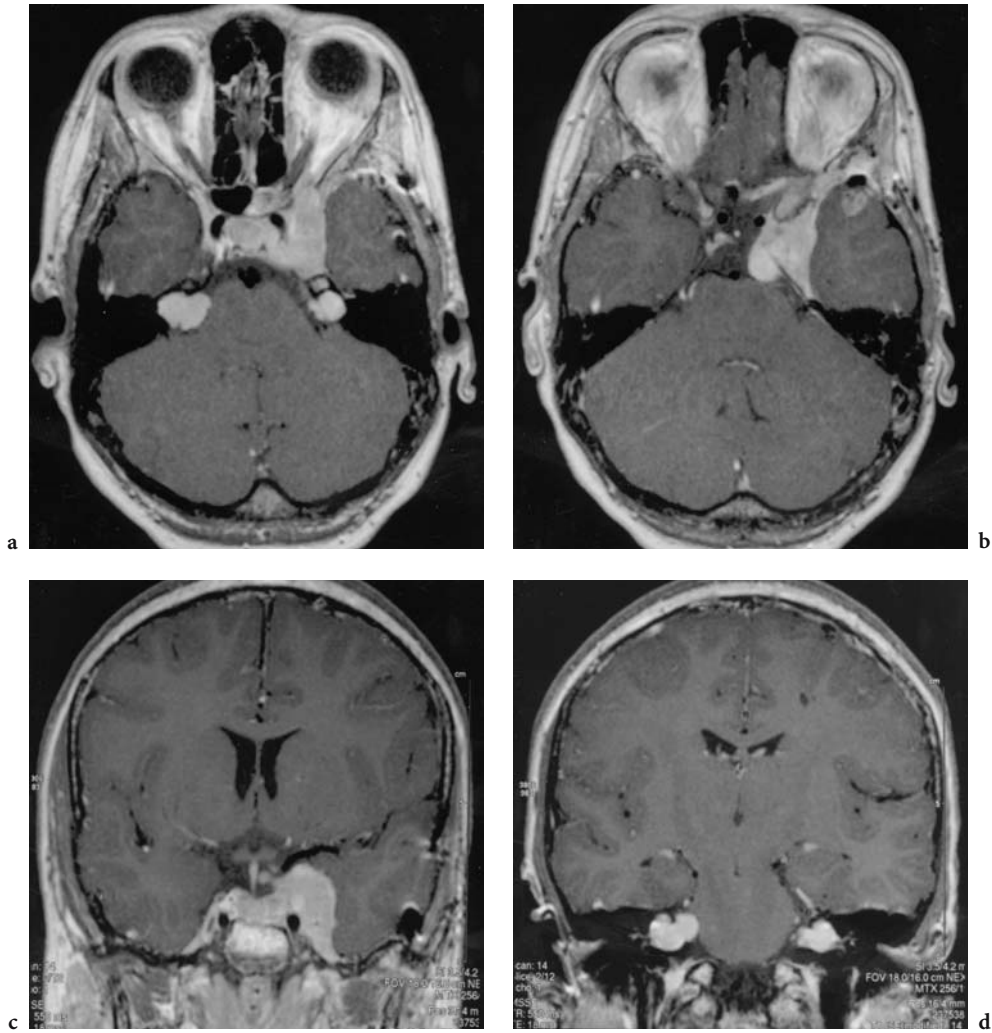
T1-weighted, contrast-enhanced MRI of newly diagnosed NF2 in a 14-year-old girl. MRI shows bilateral acoustic neuromas, meningioma at tip of left temporal lobe, mass (presumably a meningioma) in suprasellar/left parasellar/sphenoid area
